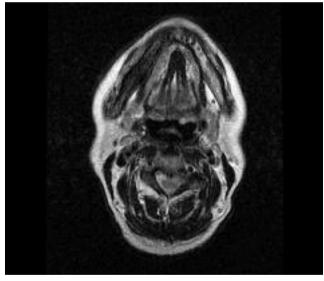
MRI demonstrating osteonecrosis (low intensity on T2 weighted images) in the mandible of a patient with a history of having received zoledronic acid therapy.
